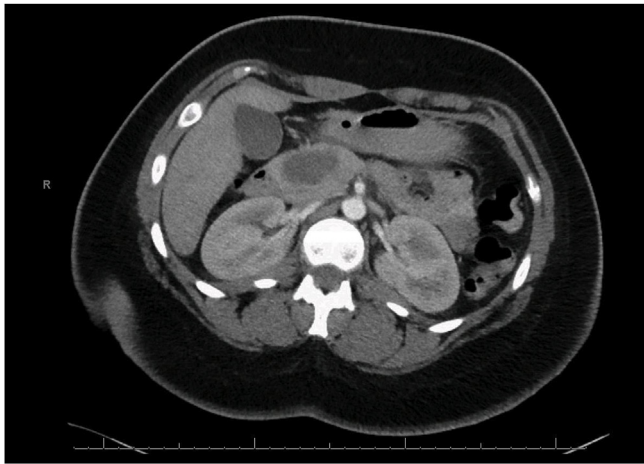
CT abdomen with contrast for patient A.
